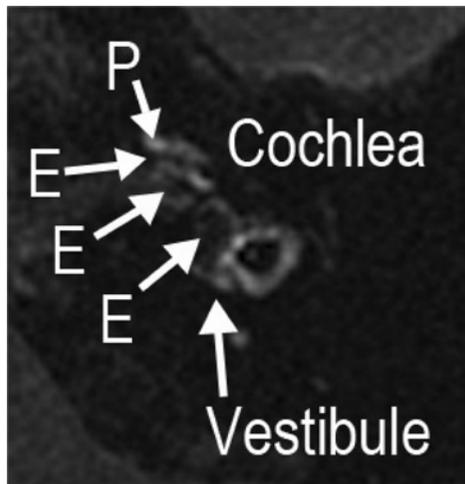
MRI of a normal (non-hydroptic) ear. P = perilymph; E = endolymph.
